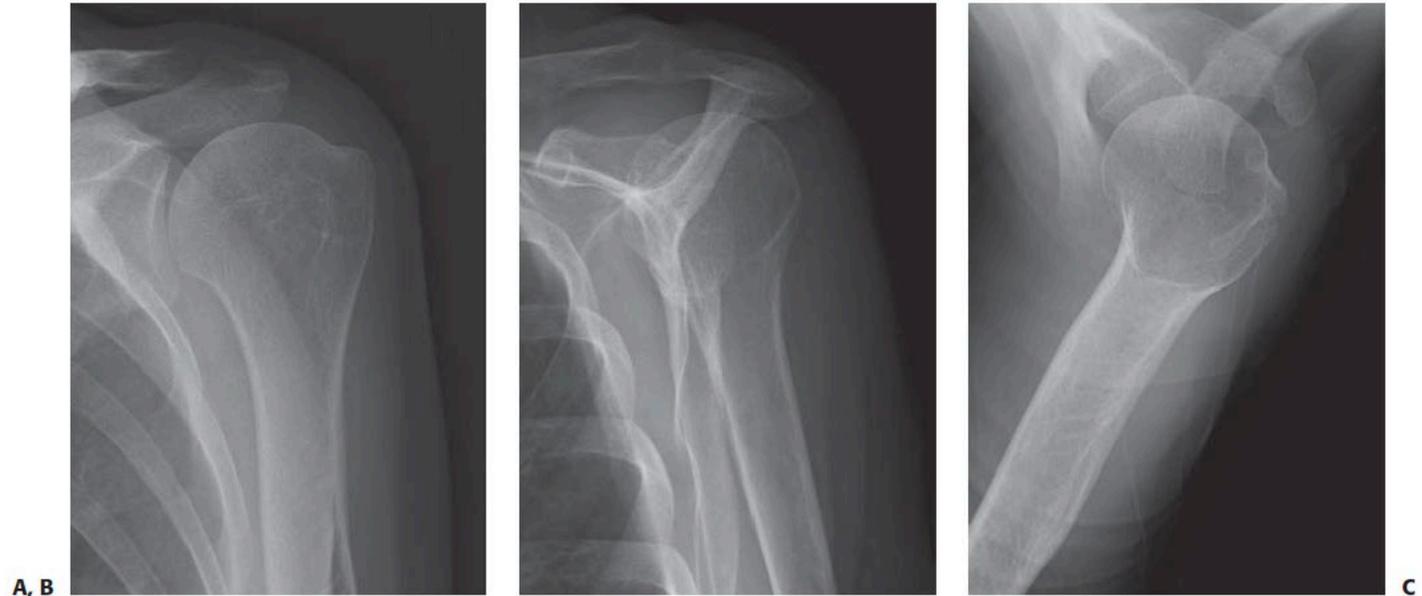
Radiographic trauma series. A: AP Grashey view of the left shoulder. Note the tangential view of the glenoid articular surface. B: Neer lateral (Y) view of the left shoulder. C: Axillary view. Note how the humeral head is centered on the glenoid in the transverse plane.
